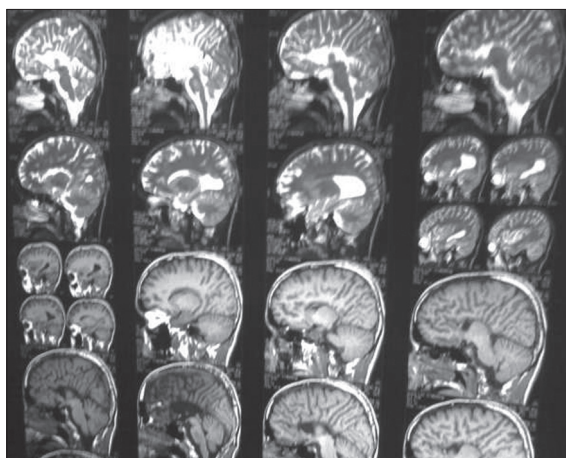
The sagittal sections of the T2-weighted imaging replicating earlier findings
